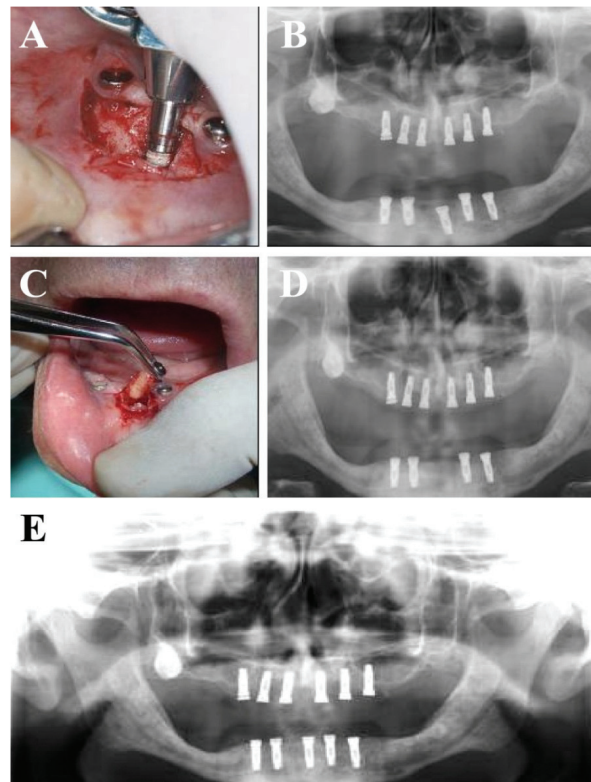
Bonelike[®]-coated cp Ti dental implants clinical application. (A) An implantation of Bonelike[®]-coated dental implant in the mandible; (B) Postoperative X-ray orthopantomogram; (C) After 3 months the central implant on the mandible was
